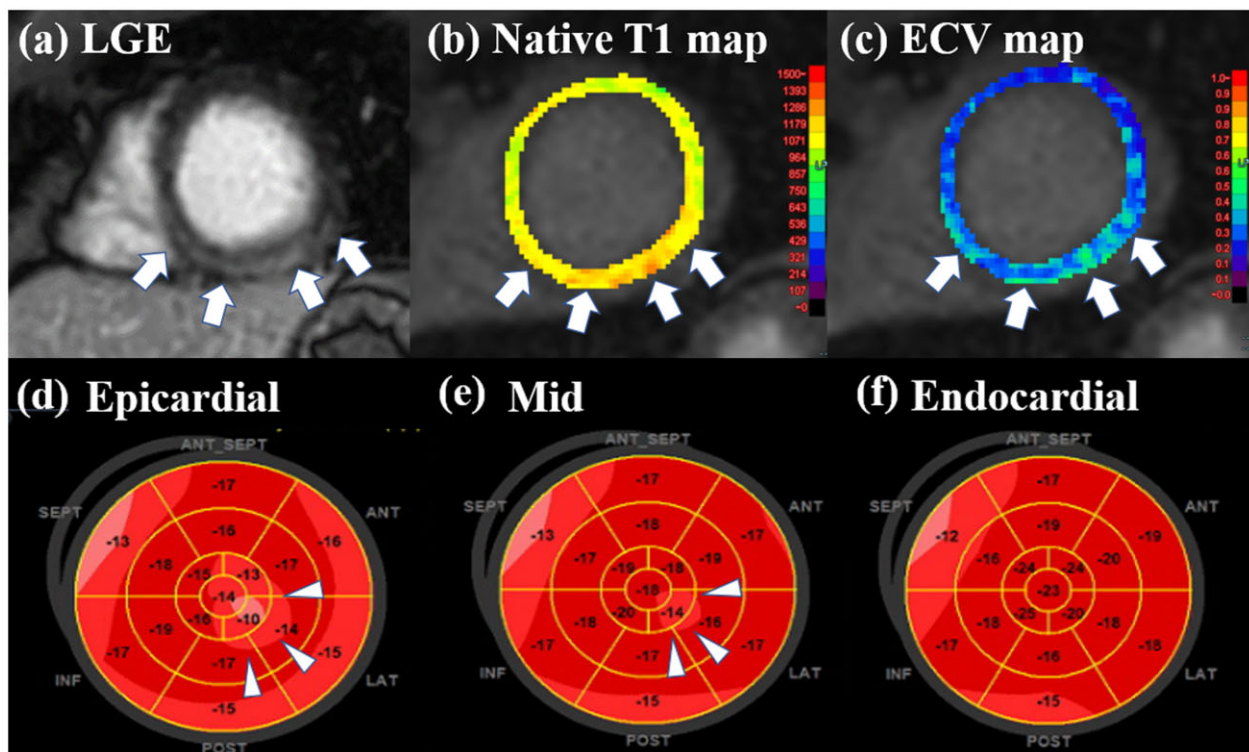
Cardiac magnetic resonance imaging (MRI) (short-axis view) demonstrated late gadolinium enhancement (LGE) in the epicardial to the mid-wall in the left ventricle inferolateral wall (arrows) (a), which are consistent with myocarditis. T1 map and extracellular volume (ECV) map showed elevated native T1 values and ECV in the regions with LGE (arrows) (b and c). Consistent with cardiac MRI findings, the values of peak systolic longitudinal strain in the inferolateral segments of epicardial (d) to the mid-layer (e) (arrowheads) were lower (–10% and –14%, respectively) than those in the endocardial layer (f) when measured by speckle-tracking echocardiography (EchoPAC Software GE Healthcare, Milwaukee, WI, USA) and left ventricular global longitudinal strain was –16.8%.
